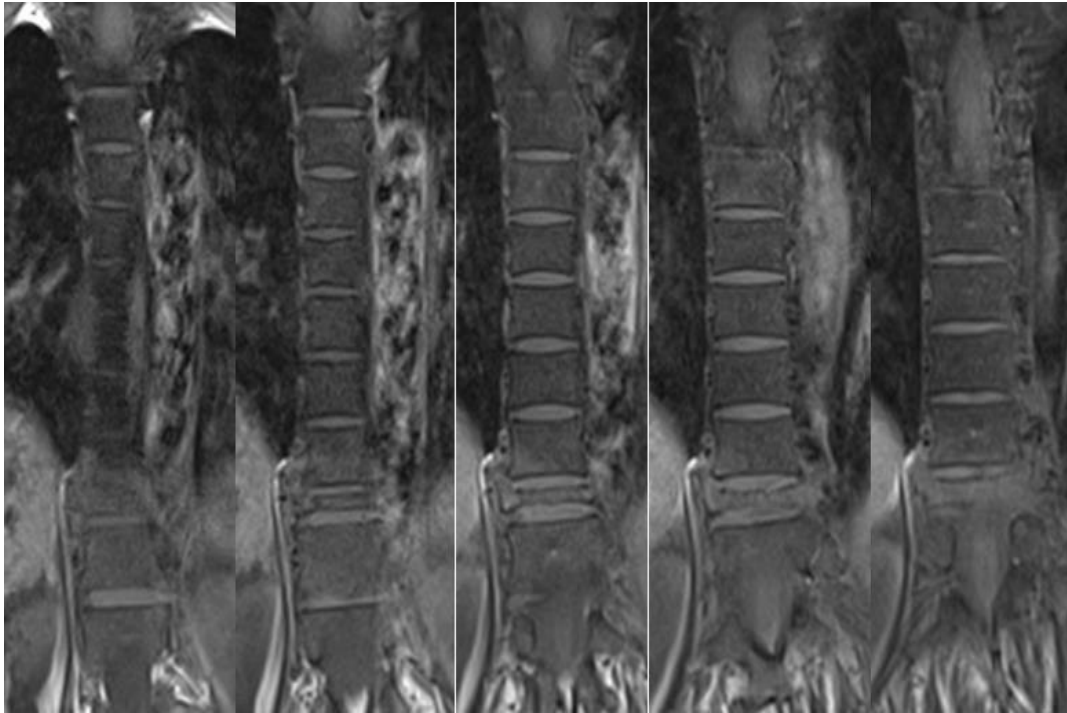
Coronal View of MRI
